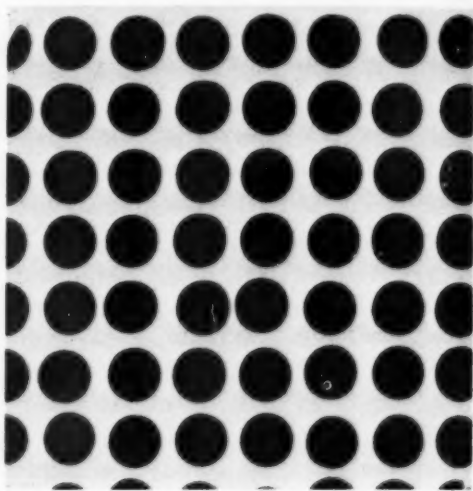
Radiograph of grid, with openings 1 cm. in diameter, 1.4 cm. between centers. Open area 40 per cent.
